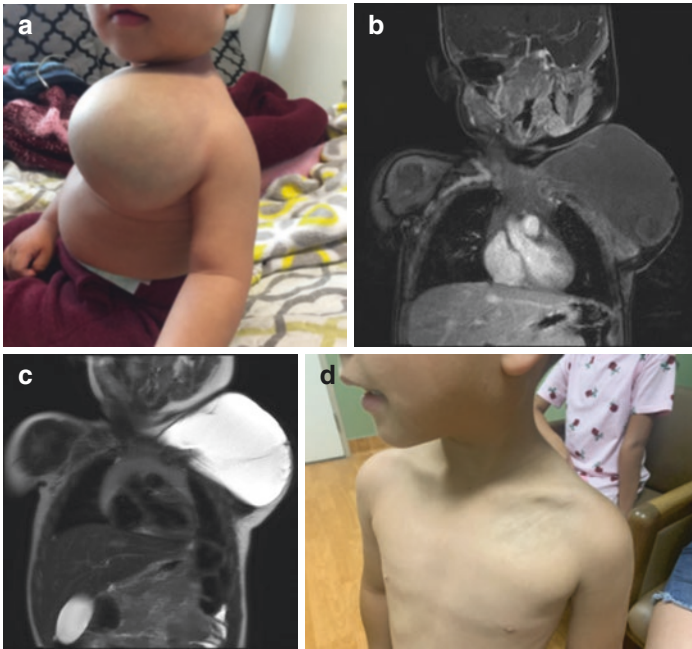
Lymphatic malformation in a 17-month-old child. (a) Photograph shows a protuberant mass in the left chest wall. (b) Coronal T1-weighted image shows the well-defined exophytic hypointense mass in the left chest wall. (c) Coronal T2-weighted image shows the well-defined exophytic hyperintense fluid intensity mass in the left chest wall. (d) Photograph shows interval resolution of the lymphatic malformation after several sessions of percutaneous sclerotherapy
